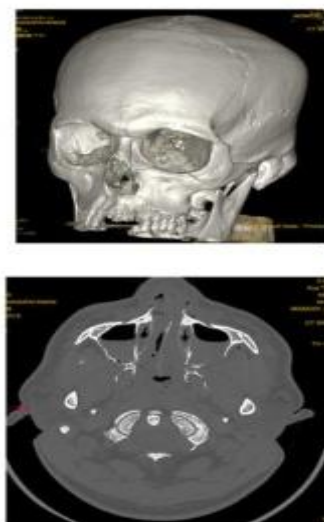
Figure 21: 3D-CT images (A), axial (B) Shows A linear fracture in the left anterior maxillary wall, medial and posterolateral wall. And fracture in the left posterolateral wall with bilateral hem sinus. Bilateral lateral pterygoid fracture noted.
